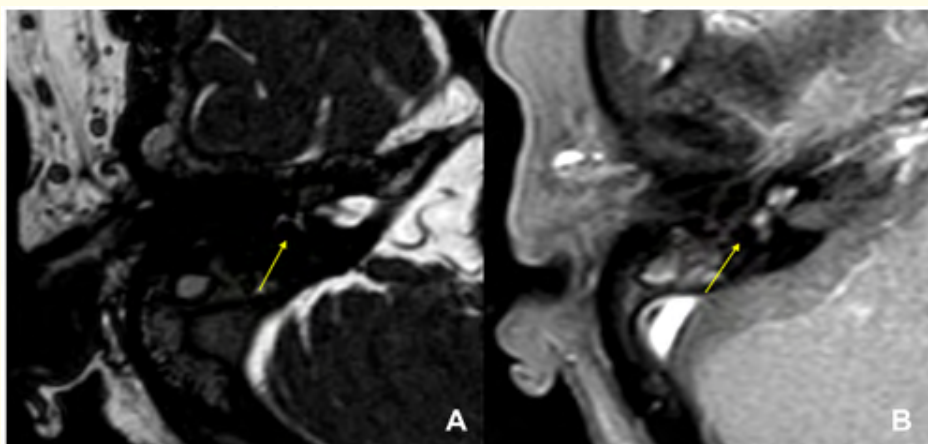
(A) Axial FIESTA sequence showing marked hypointensity of the right membranous labyrinth, reflecting loss of normal fluid signal. (B) Axial post-contrast T1-weighted image with fat suppression demonstrating delayed enhancement of the right inner ear structures, consistent with inflammatory involvement.
